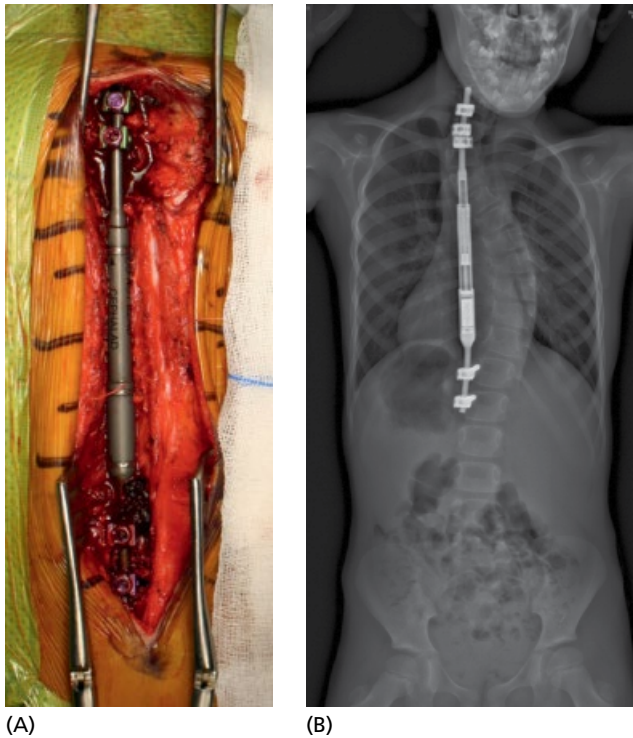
(A) Implantation of a Magec® magnetic growing rod. (B) Radiograph of Magec rod for scoliosis secondary to neurofibromatosis. (C) Lengthening of a Magec rod in the office without general anesthesia; the amount of lengthening is controlled externally. *Source:* Reproduced from Cunin [17] with permission of Elsevier.
